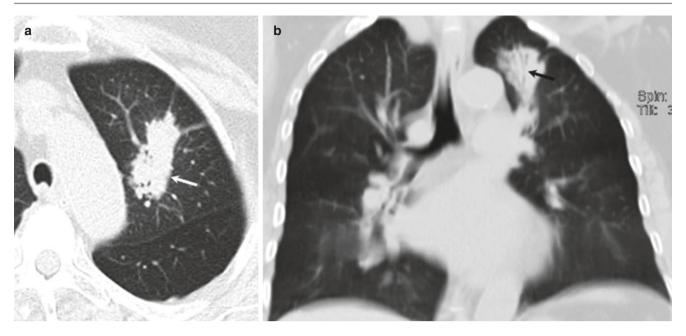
A 65-year-old women with adenocarcinoma. (a) Axial and (b) coronal CT images show an area of consolidation with air-bronchograms that was persistent on serial radiographs (not shown) (arrow)
